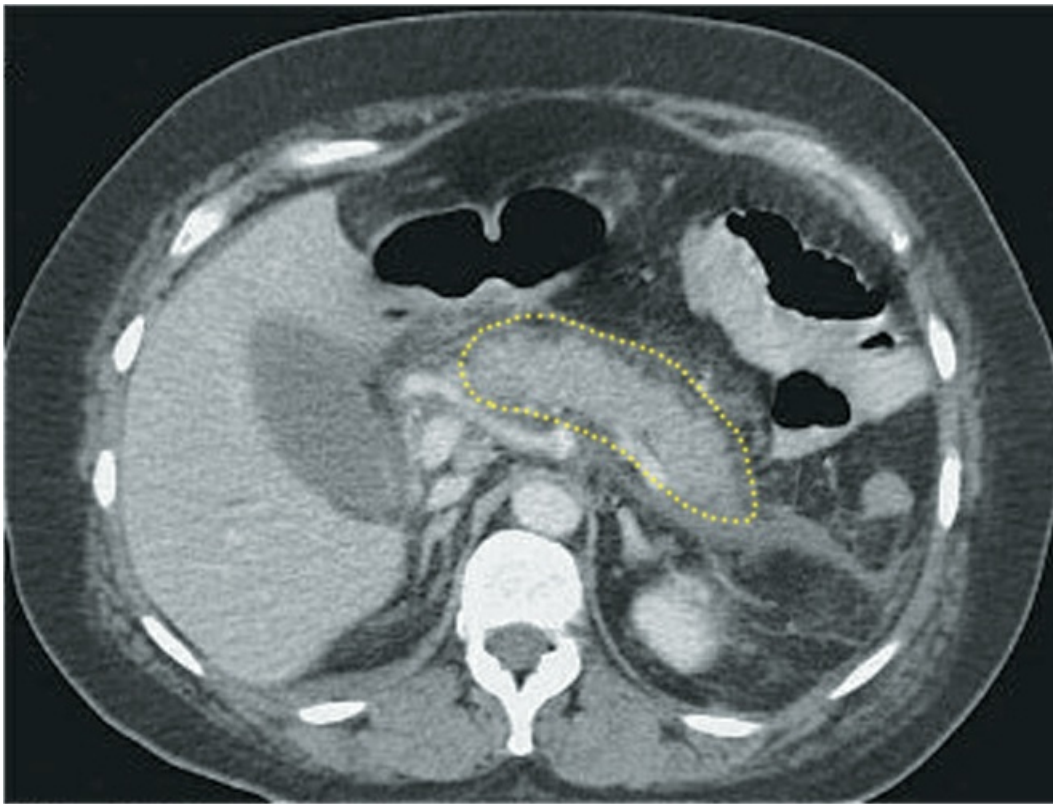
Contrast-enhanced CT image showing edematous pancreatitis. The pancreas (outlined by the dotted line) is enlarged and enhances completely. There is also blurring of the pancreatic border, which is characteristic of edema formation.
